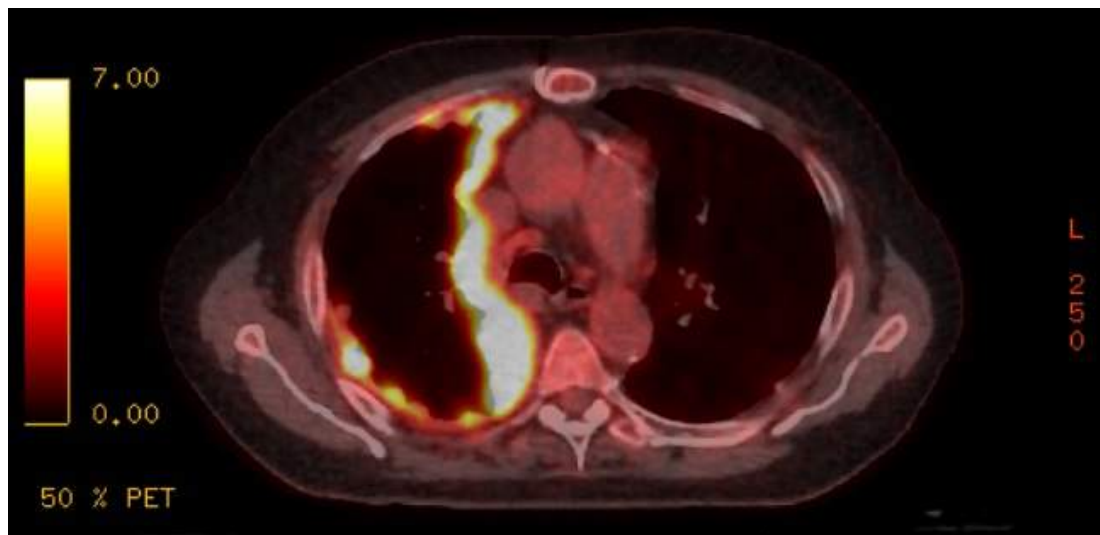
Axial ^{18}F FDG-PET-CT image of a patient with Malignant Pleural Mesothelioma, taken at the West of Scotland PET centre 2013, demonstrating intense ^{18}F FDG uptake within pleural tumour
